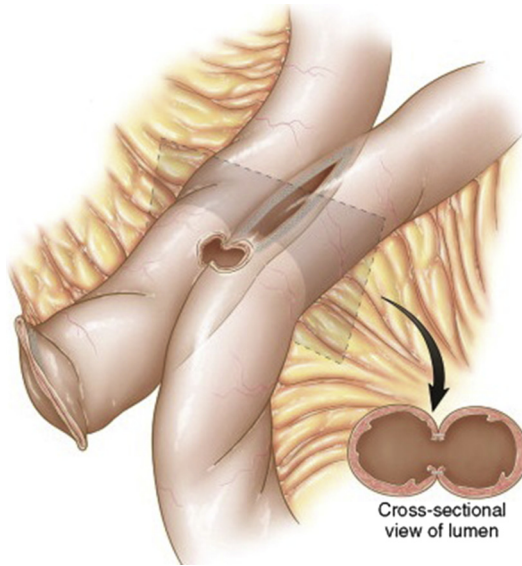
Defect created after stapler removal. (From Zografakis JG, Frantzides CT. Laparoscopic Gastric Bypass with Roux-en-Y Gastrojejunostomy. In: Frantzides CT, Carlson MA, editors. Atlas of Minimally Invasive Surgery. Philadelphia: Elsevier Saunders; 2009. p. 53–66; with permission.)
